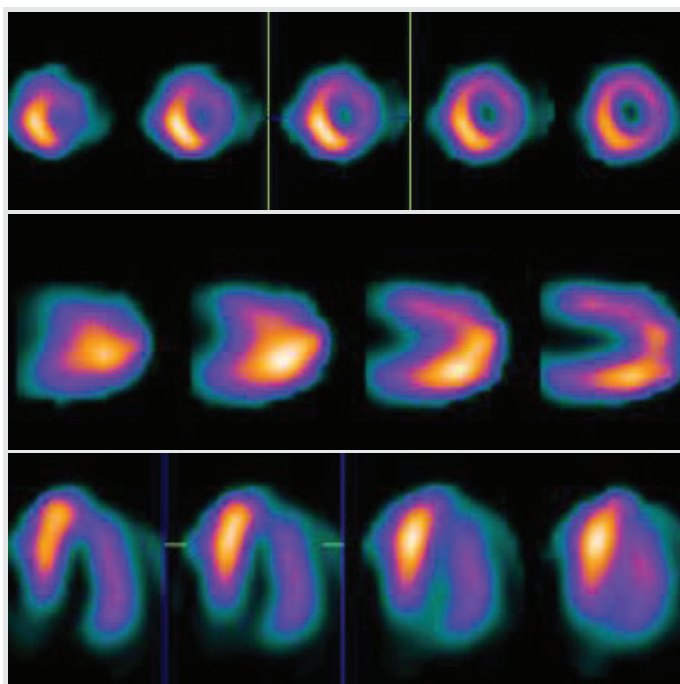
Reconstruction of single photon emission CT images in short and long axes show uniform and intense myocardial uptake of ^{99m}Tc-Pyrophosphate, most prominent in septum and inferior wall.
